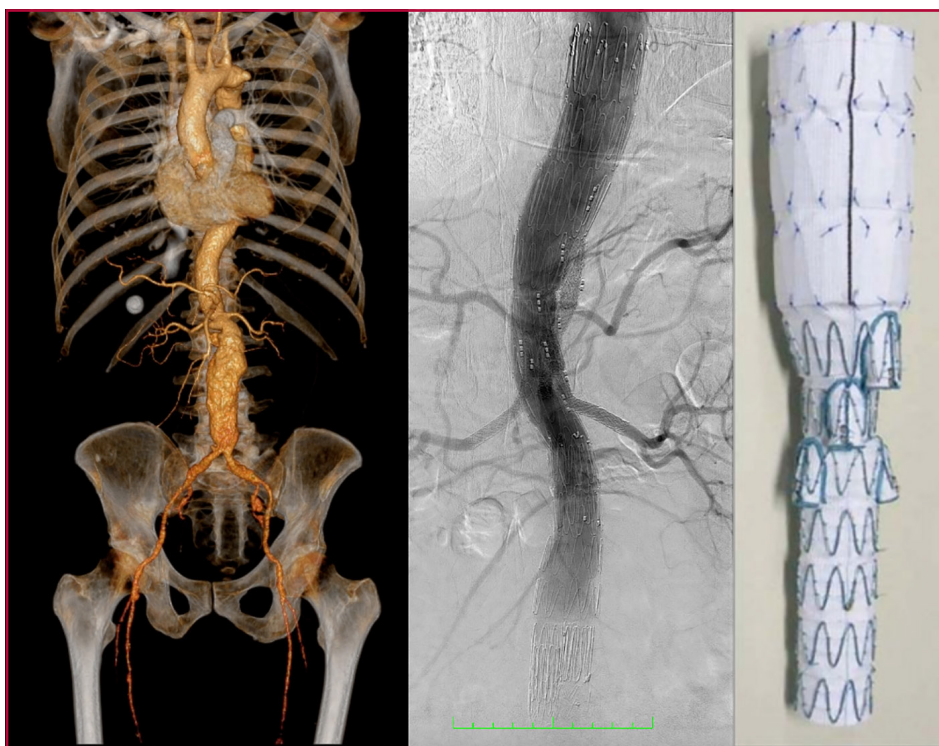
Left: Computed tomography angiography of a patient with juxta-visceral aneurysm. Center: Final angiography with branched endograft towards the celiac trunk, the superior mesenteric artery and both renal arteries. Right: Photograph of the branched endograft.
